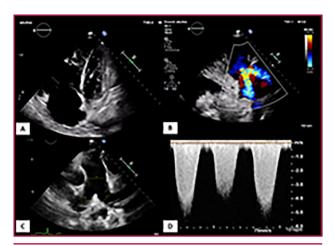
Transthoracic echocardiography on admission. Apical 4-chamber planes (A) modified parasternal long axis over RV (B), parasternal short axis at the level of great vessels (C) and continuous Doppler over tricuspid regurgitation flow (D). Figure (A) shows severe RV enlargement and dysfunction, with severe functional tricuspid regurgitation (B). Enlargement of the pulmonary artery. The RV-RA gradient of tricuspid regurgitation by Doppler is 120 mmHg (D), suggestive of severe PH. PH: pulmonary hypertension. RA: right atrium. RV: right ventricle
